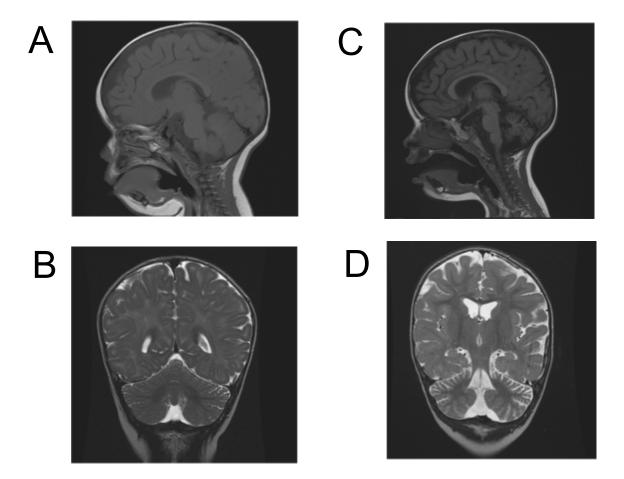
Figure e-1: MRI images from patient III. Initial sagittal T1 (panel A) and coronal T2 images (panel B) at 7 months of age (panel A) showed a normal cerebellum but presumed benign enlargement of the subarachnoid space of infancy. Follow-up sagittal T1 Flair (panel C) and coronal T2 (panel D) images at age 2 showed mild diffuse and symmetrical brain atrophy with progression in the cerebellum as compared to the prior scan.
